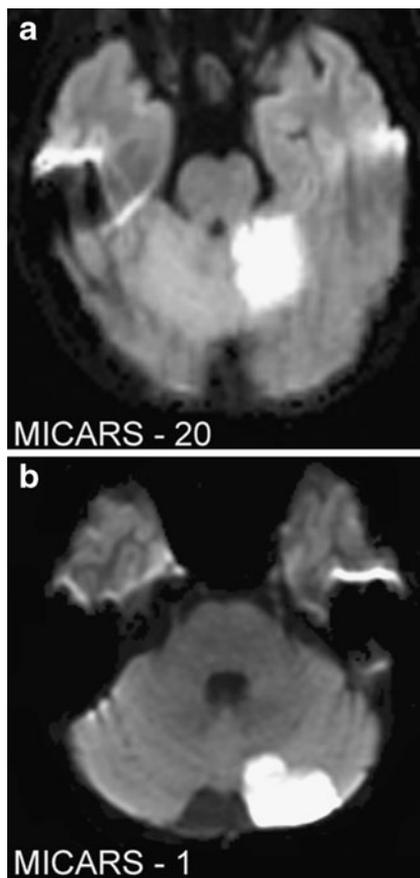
Representative axial sections of diffusion weighted MRI in patients with acute cerebellar stroke. a infarction in the anterior lobe (lobules III through V), with an ipsilateral cerebellar motor syndrome of moderate degree (MICARS, 20). b infarction confined to the posterior lobe, involving lobule VI, crus I and crus II. This patient had no ataxia or dysmetria (MICARS 1). MICARS, Modified International Cooperative Ataxia Rating Scale (Trouillas et al. 1997; Schmahmann et al. 2009b)
